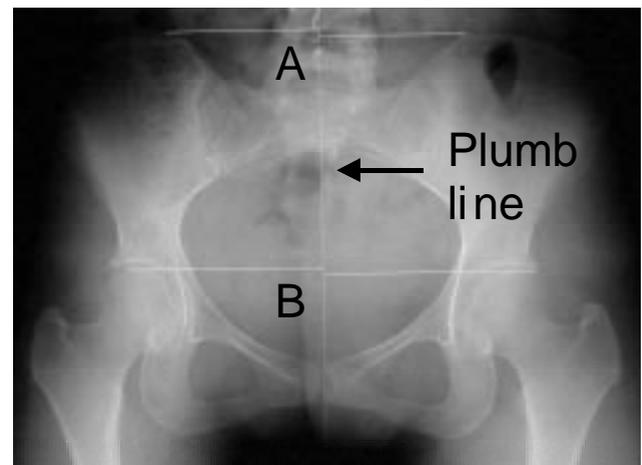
Standing anterior-posterior radiograph of the pelvis. The plumb line is the true vertical while horizontal lines are drawn at right angles to the superior aspect of the iliac crests and femoral heads. The vertical distance between the 2 lines represents the amount of pelvic crest height difference (A) or leg length (femoral head height) difference (B).
